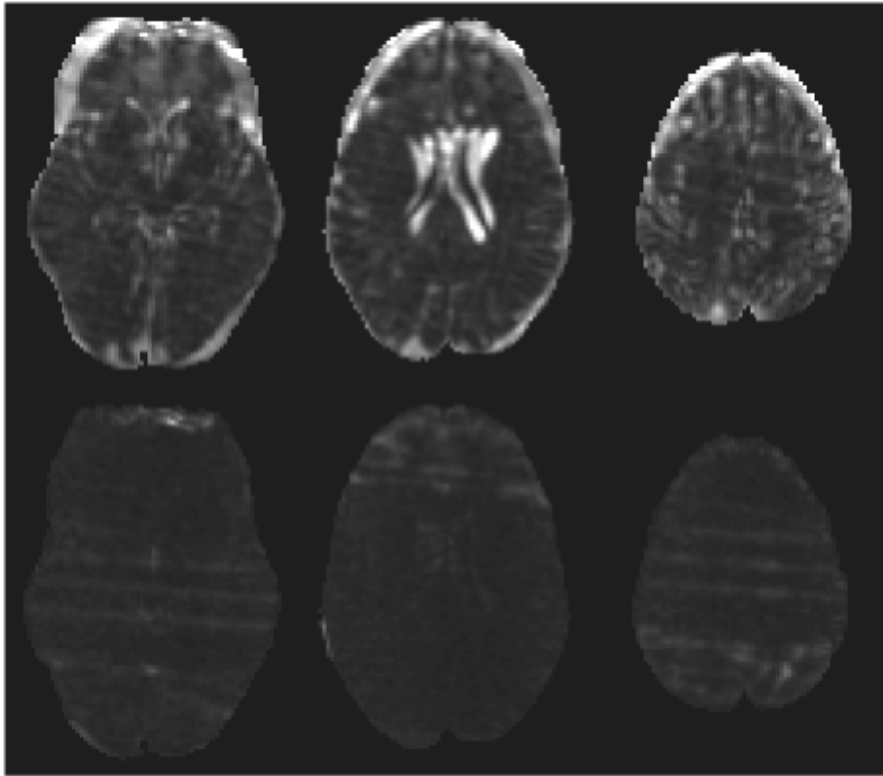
Axial views of the fit of the diffusion tensor for three representative slices. Top row: fit without alignment. Bottom row: fit from DWIs corrected for alignment. The chi squared error between the ADT model and the DWI data is significantly reduced after motion and distortion correction, indicating better image alignment.
